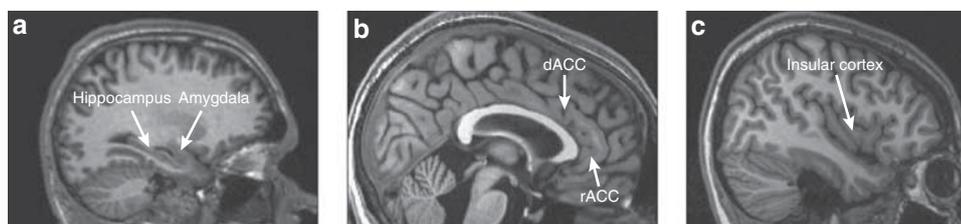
Magnetic resonance images (sagittal slices) showing the structures of interest in this review: (a) the hippocampus and the amygdala; (b) the dorsal anterior cingulate cortex (dACC) and the rostral anterior cingulate cortex (rACC); and (c) the insular cortex.
